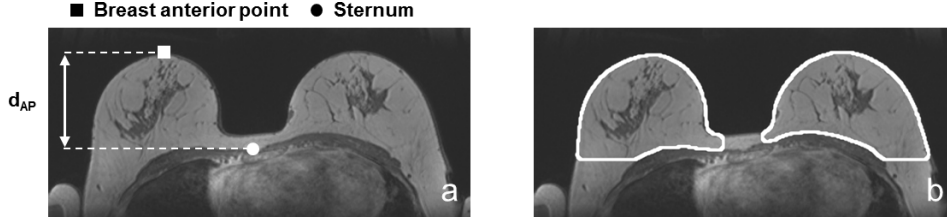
Automatic breast segmentation: axial slice of pre-contrast DCE-MRI volume  $T_0$  with (a) breast size measured as  $d_{AP}$  and (b) its breast segmentation.
